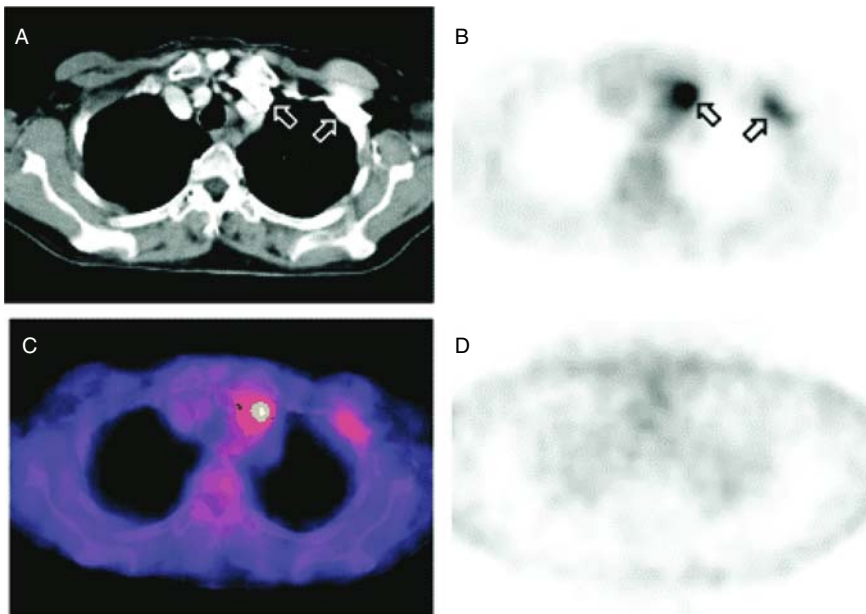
Contrast-enhanced related artefact in PET/CT imaging. Bolus passage of intravenous contrast agent in left subclavian and brachiocephalic veins on CT (A, arrows) led to areas of apparently increased glucose metabolism on CT-based attenuation corrected PET (B, arrows). On fused PET/CT images, this area of apparently increased glucose metabolism correlated with high-density contrast in venous system on CT (C). Reconstructed PET images without attenuation correction demonstrated homogeneous tracer distribution (D), demasking areas of apparently increased glucose metabolism as artefact. Reprinted with permission from ref.⁸⁶
